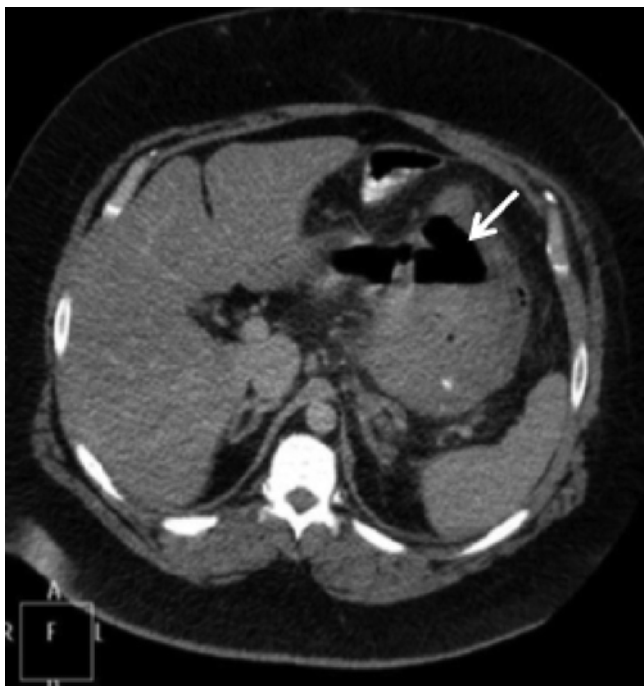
Delayed post-LSG leakage presenting as an abscess in CT scan (arrow)
